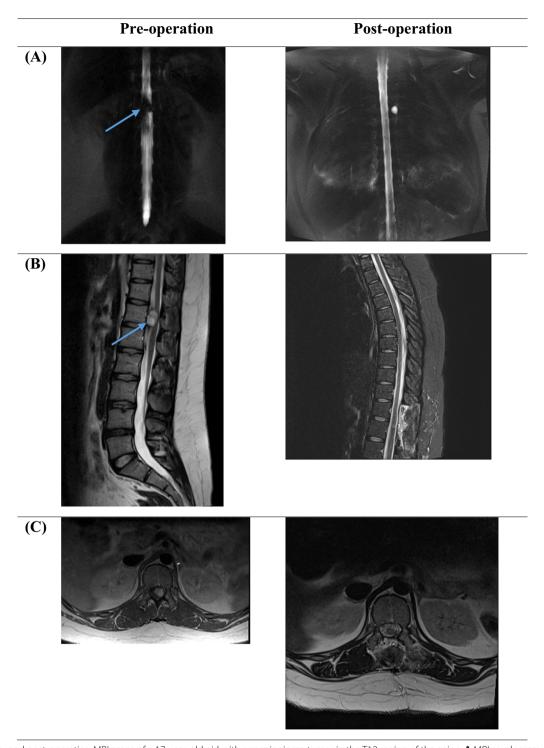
Pre- and post-operation MRI scans of a 17-year-old girl with a meningioma tumor in the T12 region of the spine: A MRI myelogram view B Mid-sagittal T2-weighted MRI of the spine C Axial T1-weighted MRI of the T12 region of the spine. Postoperative MRI scans reveal complete removal of the tumor. Arrows show the location of the tumor
